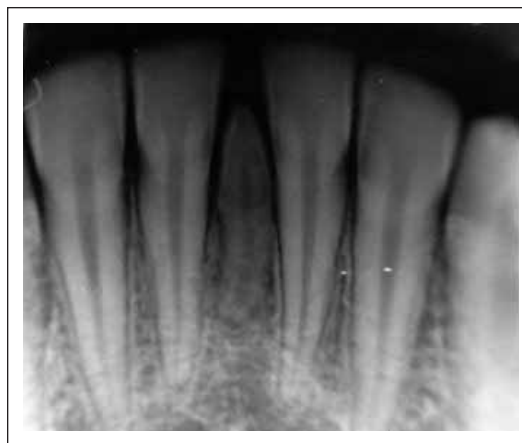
Periapical radiography showing a rotated mesiodens with an apex dilaceration.
